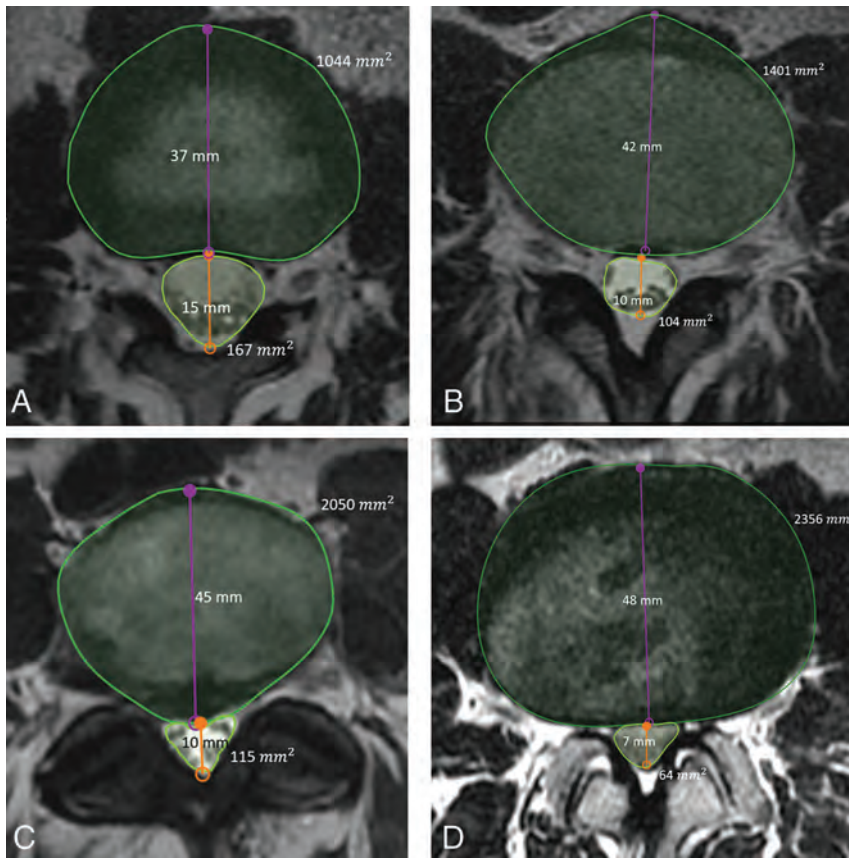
Sample T2-weighted axial MR imaging slices of the lumbar spine for each stenosis grade, determined qualitatively by a neuroradiologist, with the metrics annotated. A, Grade: normal; level, L1/L2; DSCA, 167 mm²; DSDIA, 15 mm; DDRDIA, 0.42; DDRCA, 0.40. B, Grade: mild; level, L3/L4; DSCA, 104 mm²; DSDIA, 10 mm; DDRDIA, 0.24; DDRCA, 0.27. C, Grade: moderate; level L4/L5; DSCA, 115 mm²; DSDIA, 10 mm; DDRDIA, 0.22; DDRCA, 0.24. D, Grade: severe; level, L2/L3; DSCA, 64 mm²; DSDIA, 7 mm; DDRDIA, 0.14; DDRCA, 0.16.
